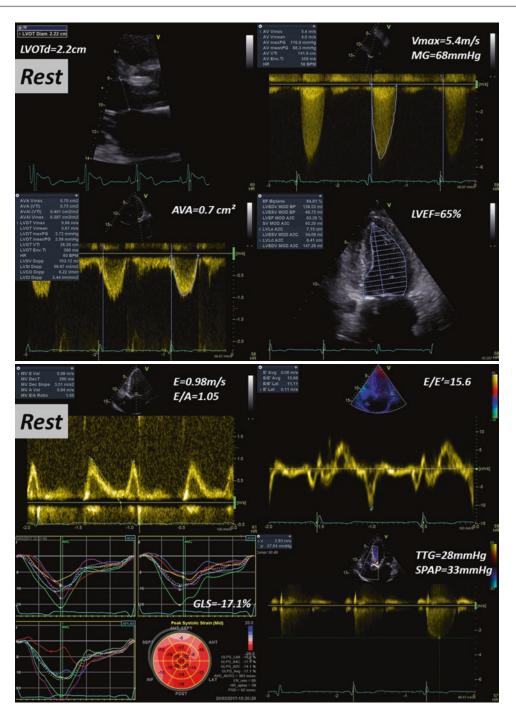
Panel a. Asymptomatic patient with severe aortic stenosis (AS). Rest echocardiography identifies a transvalvular peak velocity (Vmax) of 5.4 m/s, an aortic valve area (AVA) by the continuity equation of 0.7 cm², indicating severe AS. The left ventricular ejection fraction (LVEF) is preserved, 65% by Simpson's biplane rule. LVOTd-left ventricular outflow tract diameter; Vmaxmaximal transaortic velocity; MG-mean transaortic pressure gradient. Panel b. Rest echocardiographic evaluation pleads for elevated left ventricular (LV) filling pressures
